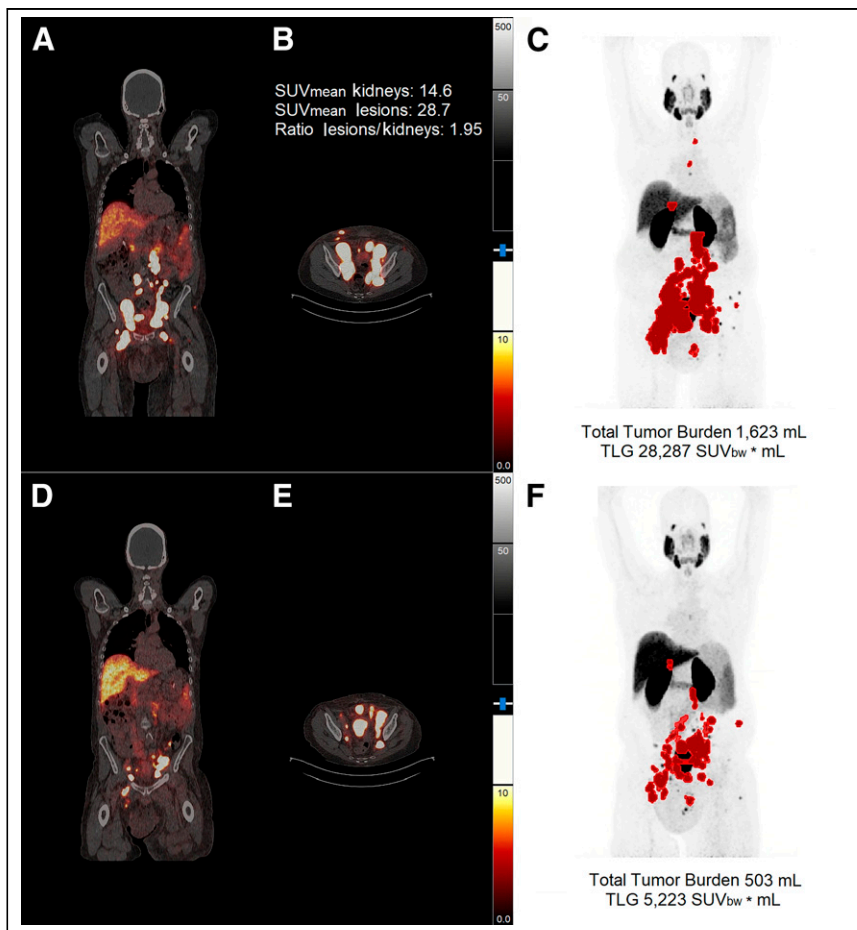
Results from one responder. (A–C) PET/CT imaging before first therapy cycle. (D–F) PET/CT imaging after 2 therapy cycles. (C and F) Maximum-intensity projections together with TTB and TLG. Lesions with SUV < 3.5 were not included. SUV_{bw} = standardized uptake value based on body weight.
